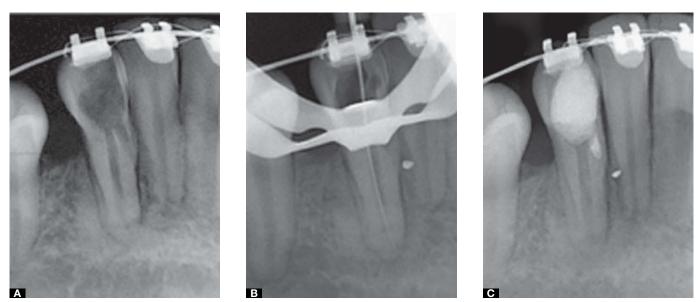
A) Initial radiograph: Excessive coronary abrasion, perforation path to mesial and radiopaque extraradicular point suggesting restorative material. B) Confirmation of the working length. C) Settling of the MTA in the perforation.
